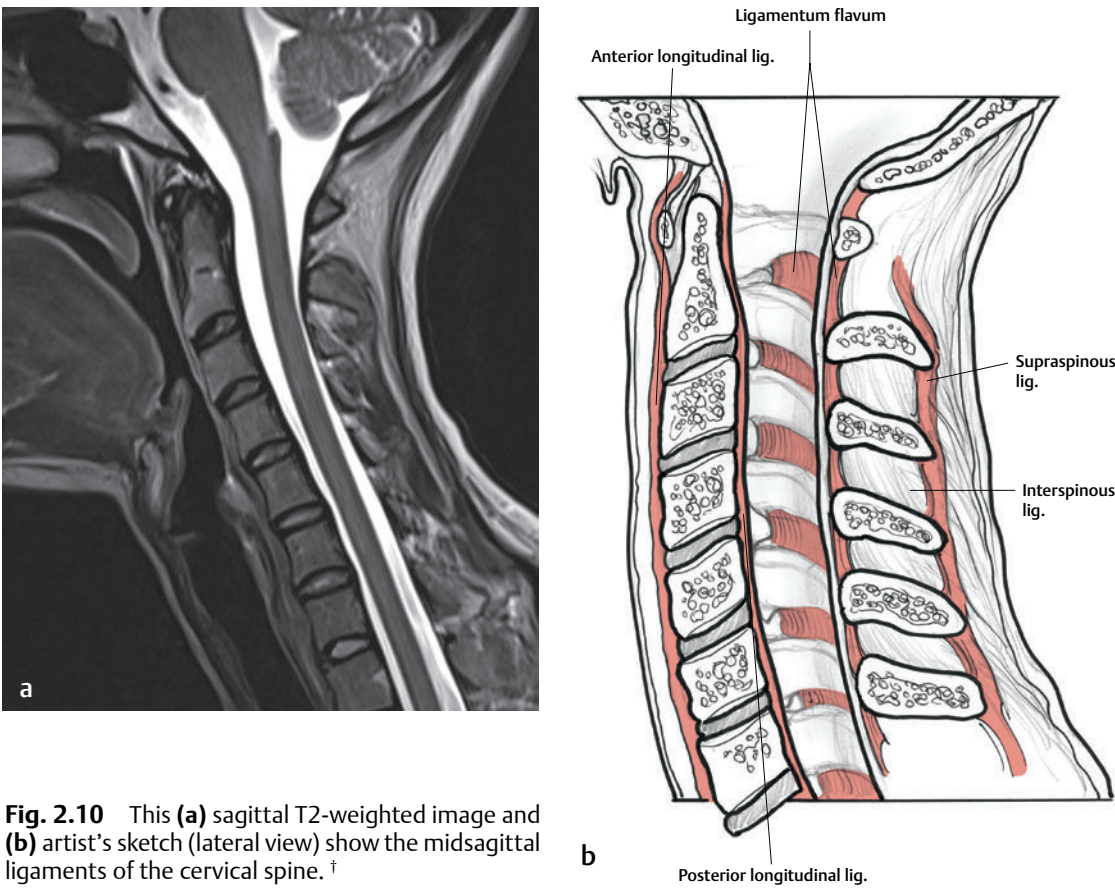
This (a) sagittal T2-weighted image and (b) artist's sketch (lateral view) show the midsagittal ligaments of the cervical spine. †
